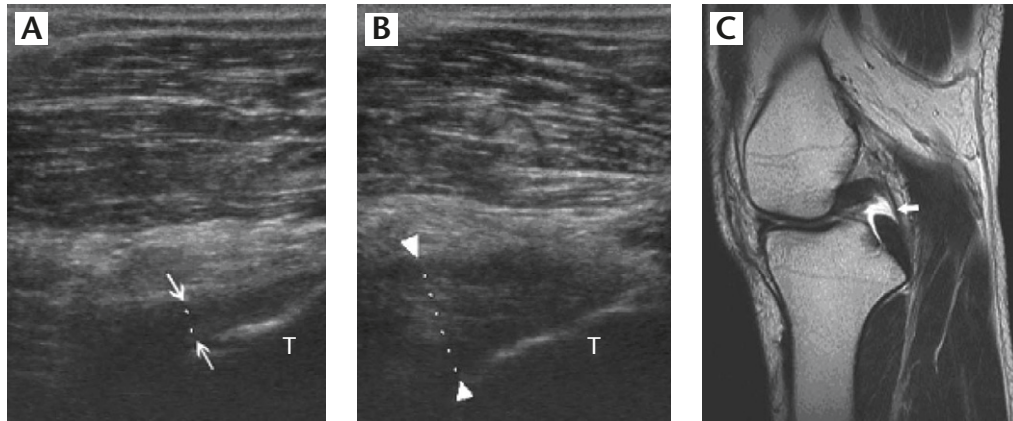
Sonograms and magnetic resonance imaging (MRI) from a 21-year-old man who had a torn left posterior cruciate ligament (PCL) caused by a traffic accident. The examination date was 20 days after the accident. (A) The right PCL appeared as a hypochoic band (arrow), with the greatest anterior-posterior diameter equal to 7.4 mm. (B) Sonogram of the torn left PCL (arrowhead) revealed increased diameter (11.3 mm). (C) MRI of torn PCL (open arrow). T=tibia.
